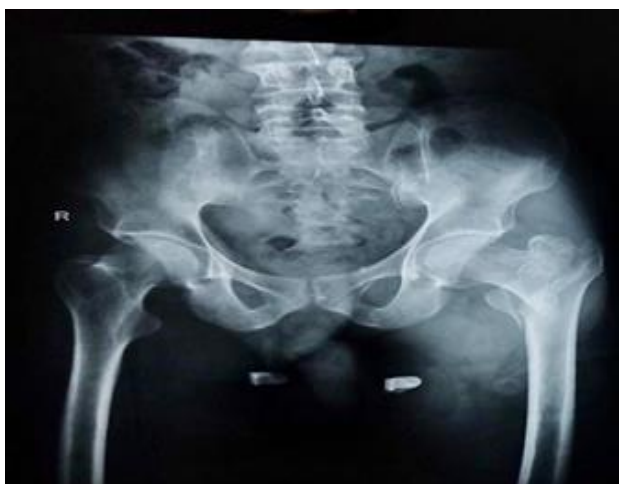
Post op X-ray of case 1.
